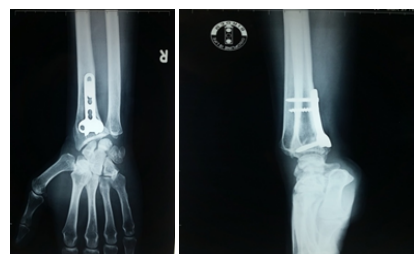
Postoperative radiographs-AP & Lateral
